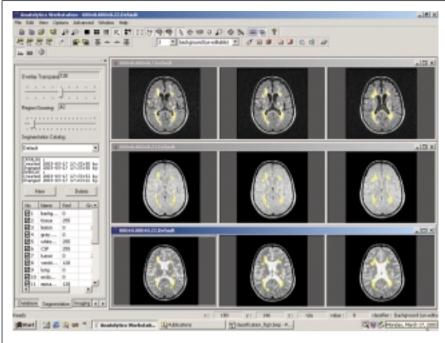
Screen shot demonstrating multi-channel segmentation of multiple sclerosis (MS) lesions. Images in the top, middle and bottom row show three consecutive sagittal slices of fluid-attenuated inversion recovery (FLAIR), proton density (PD)-weighted, and T2-weighted images of a patient with MS lesions, with the segmented lesions overlaid on top in cyan.
